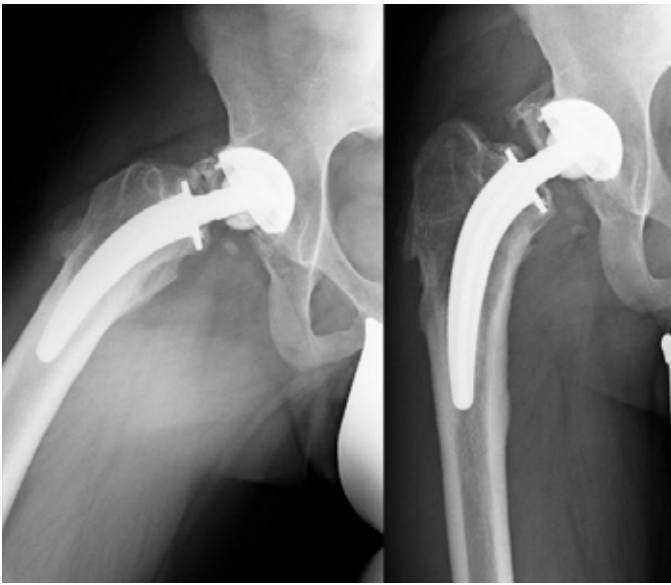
Conventional pelvic radiographs directly after trauma, revealing ceramic head fracture.
